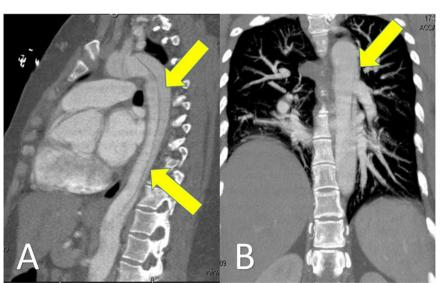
Computed tomography with angiography demonstrating aortic dissection in ascending and descending aorta (yellow arrows). (A) Lateral view. (B) Anterior view.
